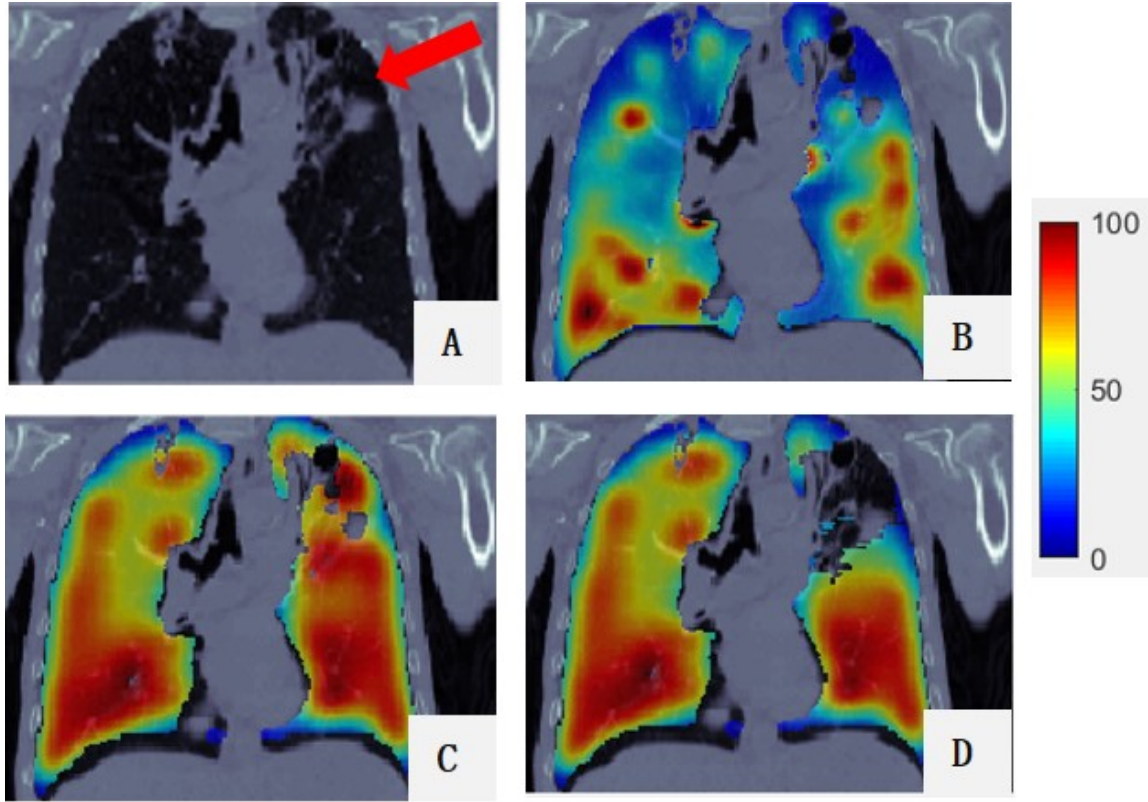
Comparison of RefVI and CTVI_{SVD} images for a representative case. (A) is CT; (B) is the RefVI of the lung region superimposed onto the CT; (C) is the origin CTVI_{SVD} of the lung region superimposed onto the CT; (D) is the corrected CTVI_{SVD} of the lung region superimposed onto the CT;. For all the figures, their 99th percentile and higher values were scaled to 100, and the minimum value was scaled to 0.
